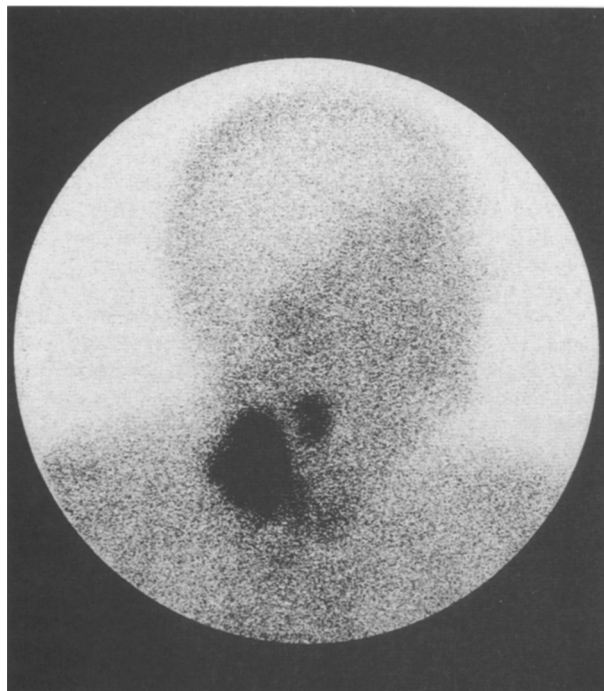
Right lateral image of the neck scanned at 24 hours in a patient with HD, nodular sclerosis subtype. The sst scintigraphy reveals positive right cervical and supraclavicular lymph nodes. Normal accumulation of radioactivity is seen in the thyroid.
